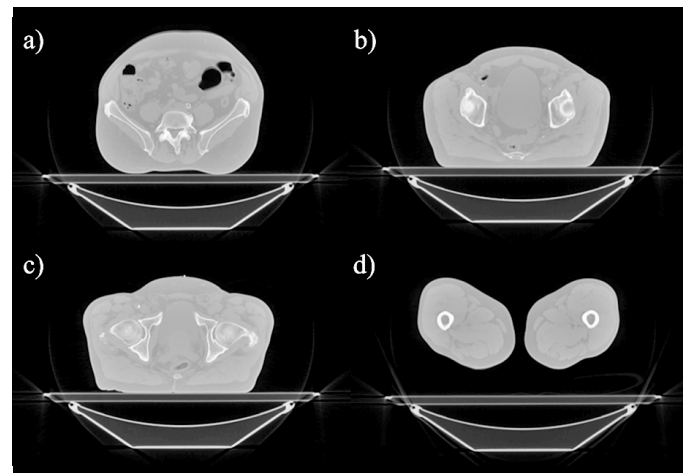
Example CT slices from training data presenting cross-section of a) sacrum and ilium b) sacrum and ilium c) ischium and upper extremity of femur d) body of femur
